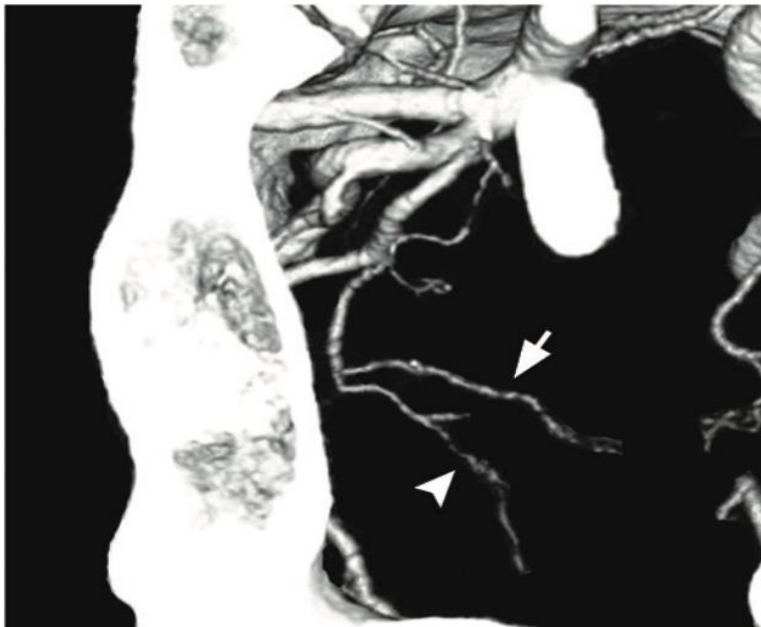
Axial CT angiogram 3D volume rendered reconstructed image of internal iliac artery showing the anterolateral/superior pedicle (arrow) and posterolateral or capsular/inferior pedicle (arrowhead) (33).
